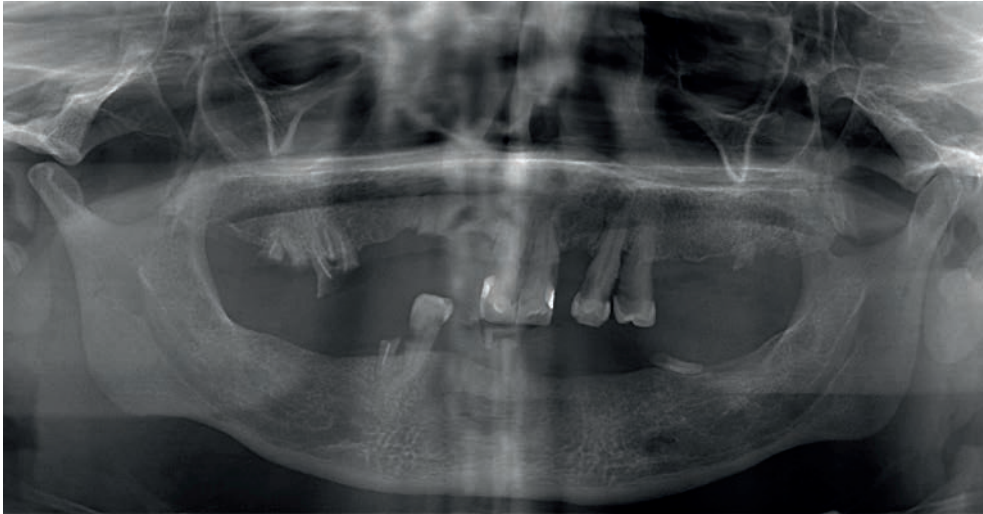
Initial examination. Radiographic presentation
